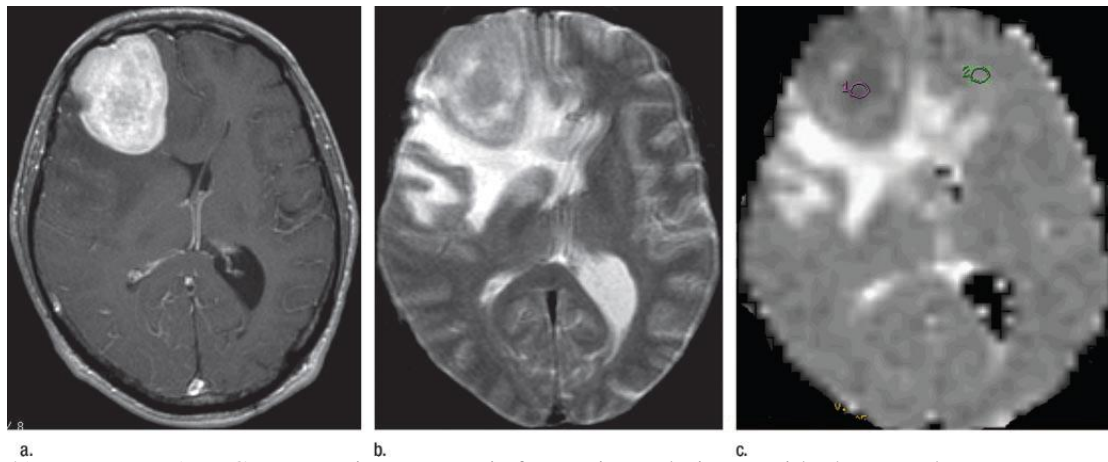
Low mean ADDC representing metastasis from primary lesion outside the central nervous system in a 62- year old man with large B-lymphoma. (a) Transverse contrast-enhanced T1-weighted MR image shows large right frontal lobe enhancing lesion with mass effect. (b) Transverse T2-weighted MR image shows signal intensity of central portion of mass is only slightly higher than that of gray matter, suggesting high cell density. (c) Transverse ADC map shows mass has lower signal intensity than normal tissue. Mean ADC in the mass region of interest (1) was 65% of that of normal tissue [PRO06].
